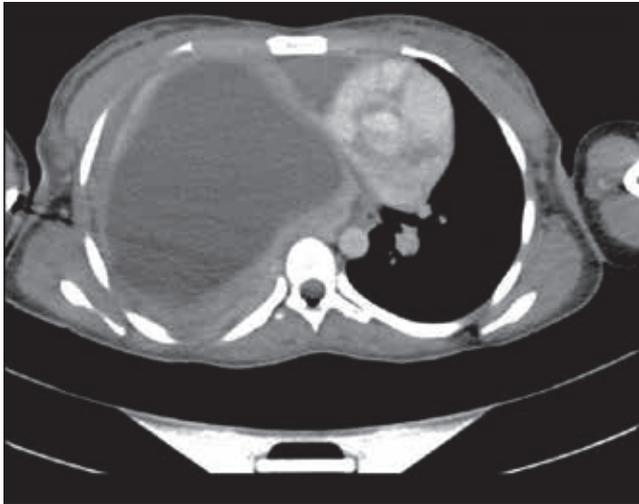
Computed tomography transversal view of patient with giant hydatid lung cyst
